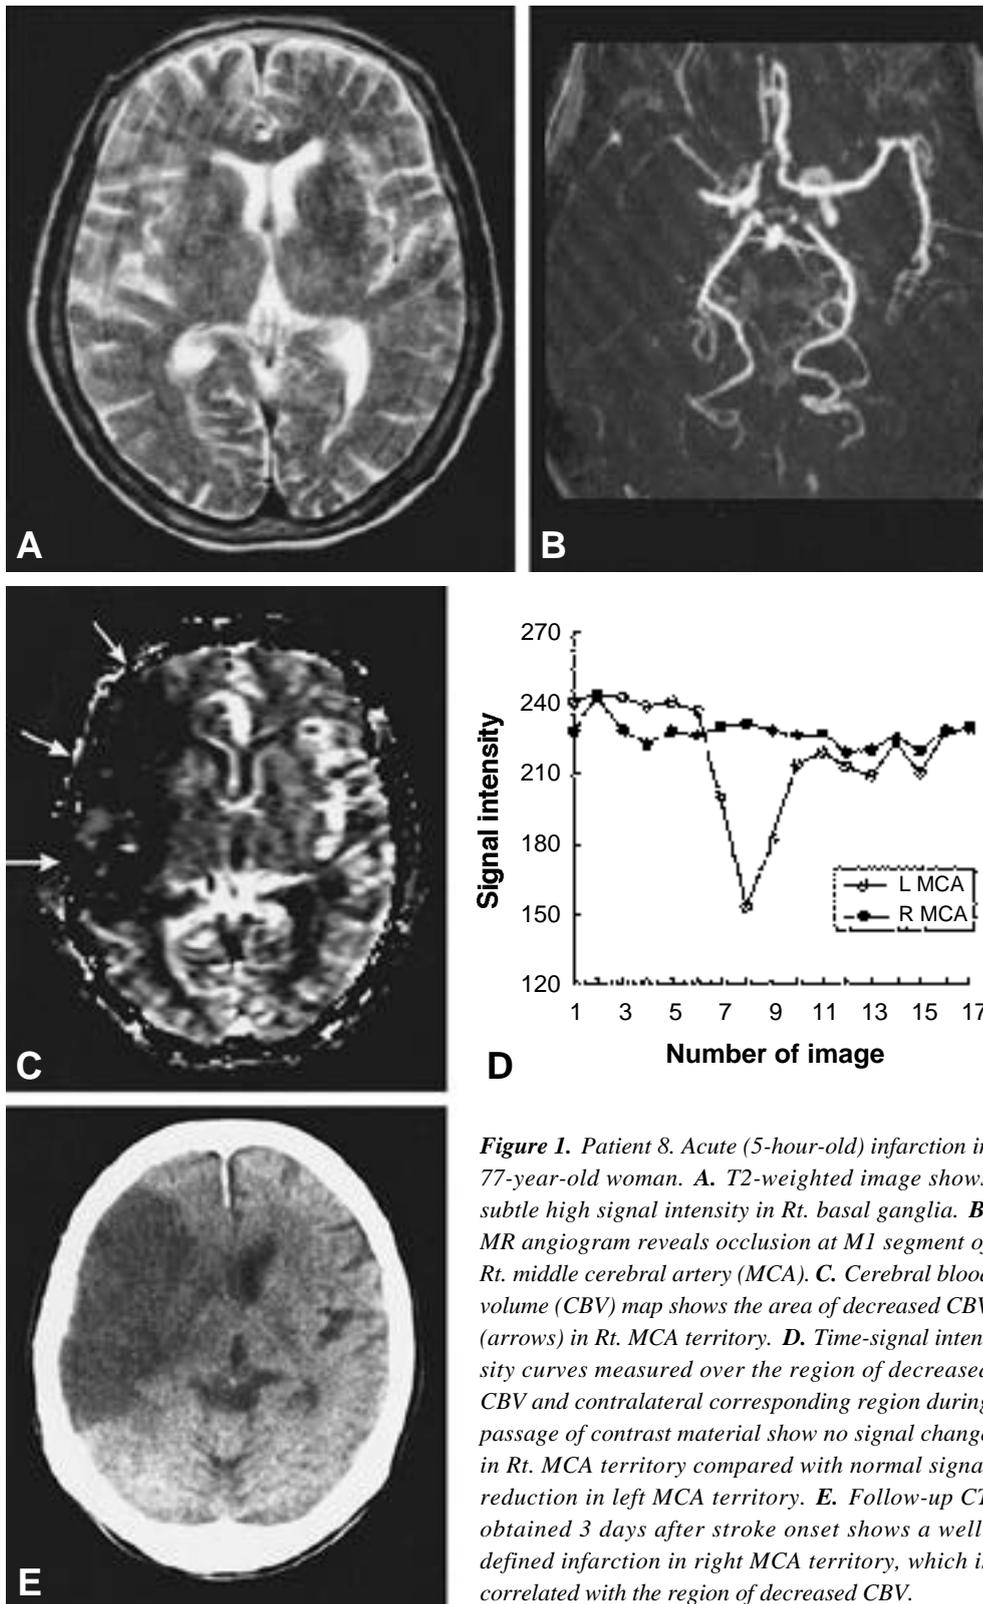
Patient 8. Acute (5-hour-old) infarction in 77-year-old woman. A. T2-weighted image shows subtle high signal intensity in Rt. basal ganglia. B. MR angiogram reveals occlusion at M1 segment of Rt. middle cerebral artery (MCA). C. Cerebral blood volume (CBV) map shows the area of decreased CBV (arrows) in Rt. MCA territory. D. Time-signal intensity curves measured over the region of decreased CBV and contralateral corresponding region during passage of contrast material show no signal change in Rt. MCA territory compared with normal signal reduction in left MCA territory. E. Follow-up CT obtained 3 days after stroke onset shows a well-defined infarction in right MCA territory, which is correlated with the region of decreased CBV.
